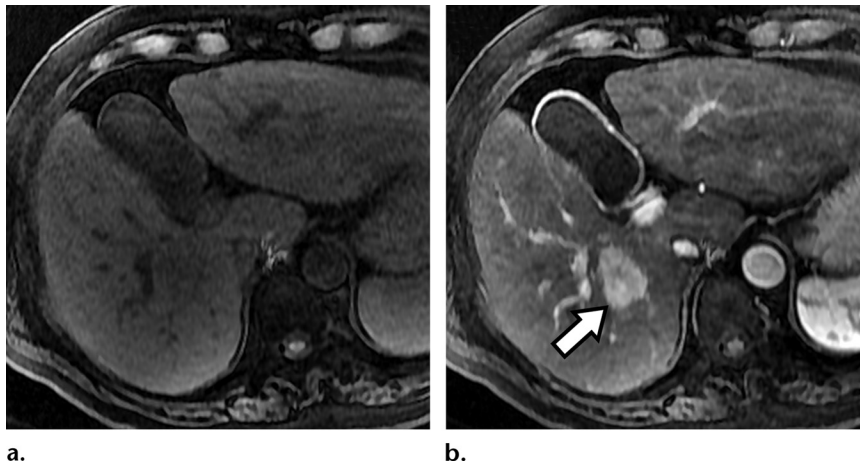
APHE in a 70-year-old man with a lesion categorized as LR-5 (definitely HCC) on the basis of major imaging features. Axial dynamic nonenhanced (a) and late arterial phase (b) MR images show a 33-mm nodule (arrow in b) with APHE.
